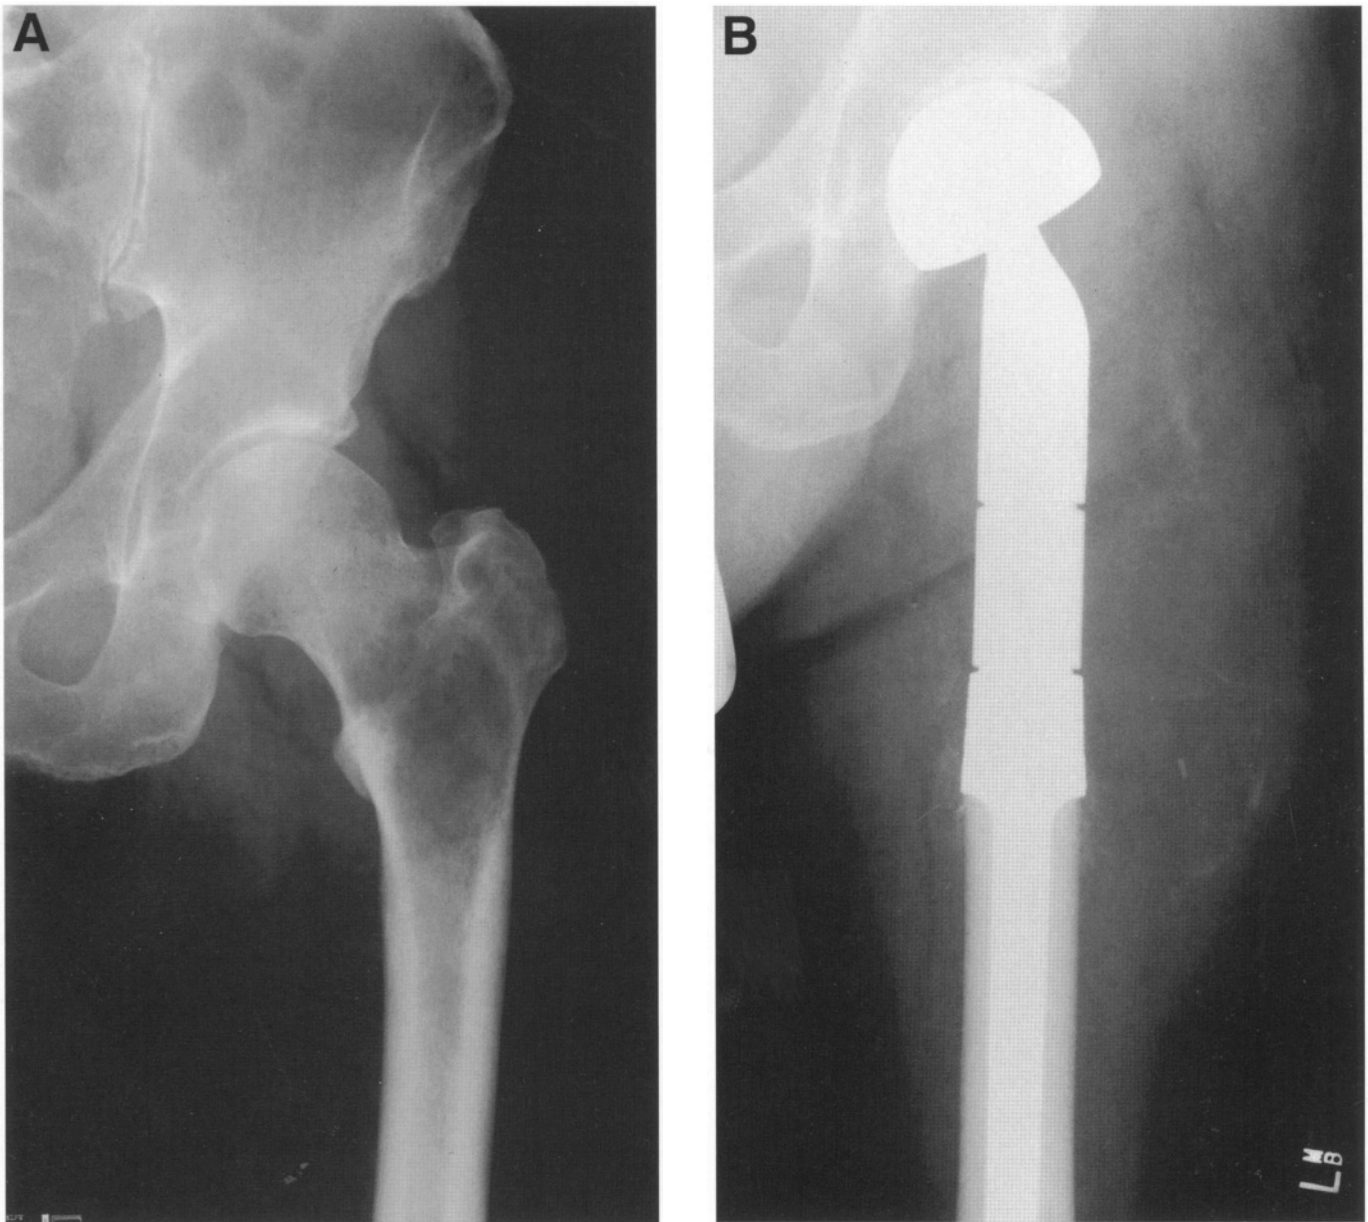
Plain radiographs showing a large lytic lesion of the proximal femur secondary to a solitary renal cell carcinoma (A). This patient was treated by a proximal femoral modular segmental replacement (B). It is the choice of the authors to utilize segmental replacements for solitary metastatic tumors, especially renal cell carcinomas, melanomas, and thyroid carcinomas.
